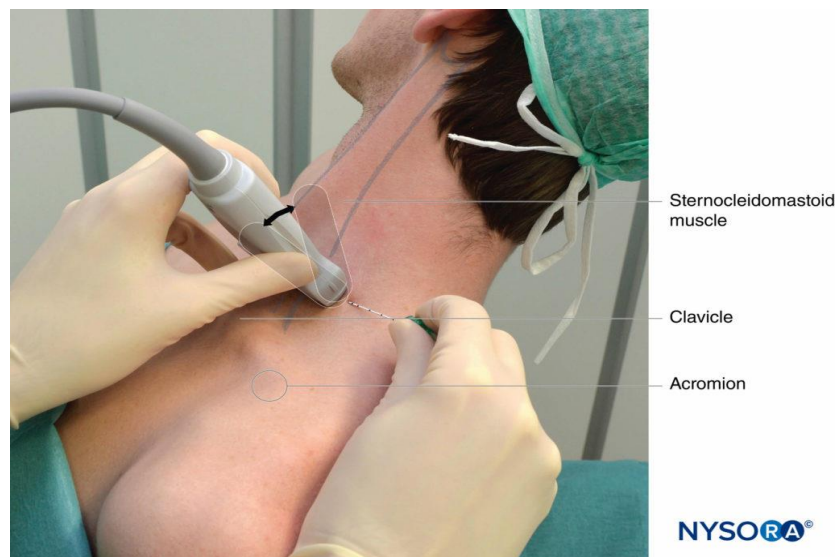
Ultrasound-guided interscalene brachial plexus nerve block: transducer and needle position to obtain the desired ultrasound image for an in-plane approach. The knowledge of external landmarks substantially facilitates and shortens the time to obtain the view necessary for nerve block performance. The transducer is positioned behind the clavicular head of the sternocleidomastoid muscle (SCM) and over the external jugular vein (not seen). The patient is in a semi-sitting position. Tilting the transducer in the caudad direction can facilitate recognition of the brachial plexus (arrow) (Brown, 2010).
